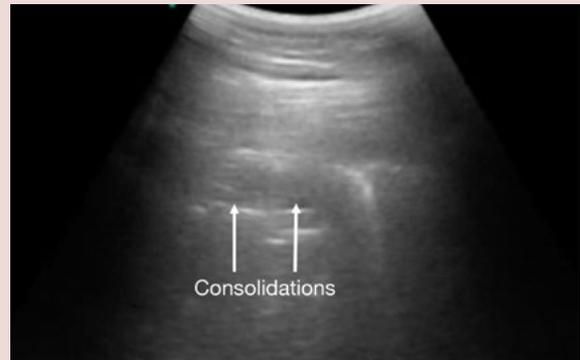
Lung ultrasound changes in a more severe case of COVID-19: Small hypoechoic consolidation in the subpleural lung area.
